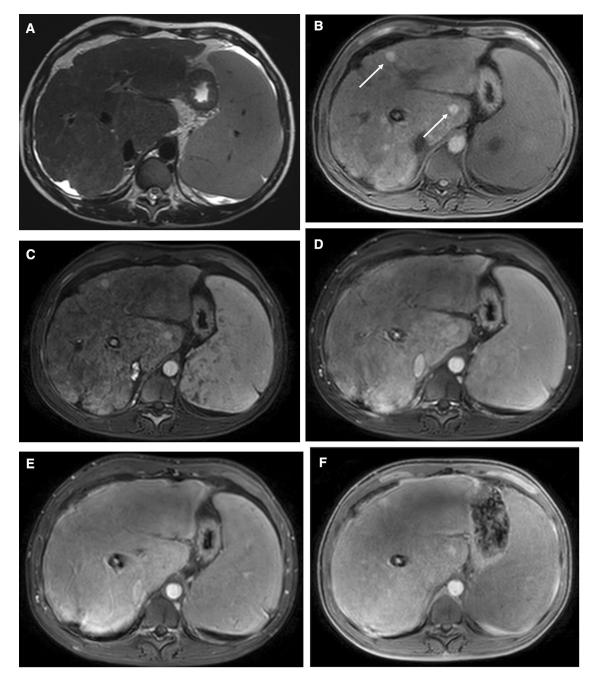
A 27-year-old female with chronic Budd–Chiari syndrome related to a myeloproliferative neoplasm. TIPS placement. Two FNH-like lesions stable over time (arrows). A On T2-weighted MR imaging, the liver nodules are not seen. B On fat-suppressed T1-weighted MR imaging, two smallsized hyperintense lesions (in segment 4 and in the caudate lobe) are observed. C On contrast-enhanced T1-weighted MR
